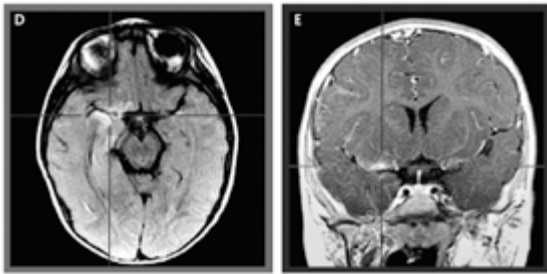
Axial, coronal, and sagittal MRI at the level of the superior cistern.
